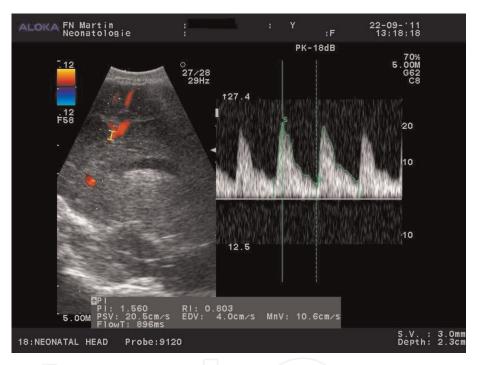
The Doppler curve of the blood flow in ACA in the neonate after severe birth trauma, the first day after birth. Decreased blood flow velocity (\downarrow Vsyst, \downarrow Ved, and \downarrow Vmean). Value of RI-ACA is significantly increased due to significant decrease of Ved.
